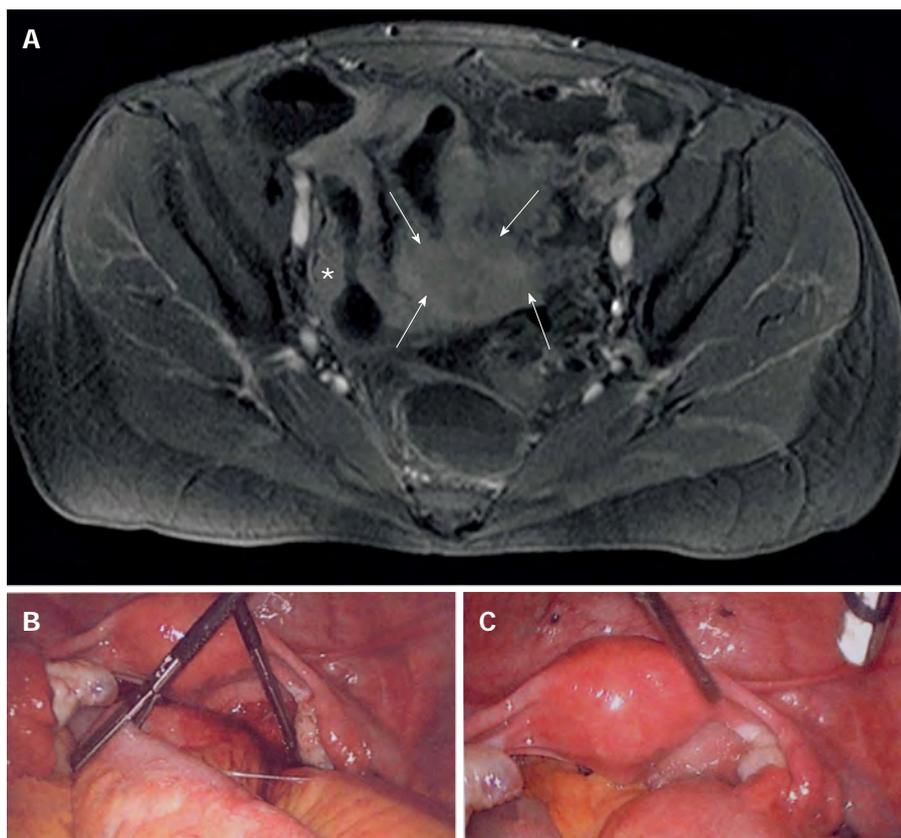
Radiological and surgical aspects of florid intestinal endometriosis and Crohn's disease coincidence. A: Magnetic resonance imaging-Sellink of the lower pelvis (axial T1 FS plus contrast agent). Bauhin's valve and coecum are marked with an asterisk. The arrows highlight an uncharacteristic tissue mass involving the bowel; B: Laparoscopically, adhesion of the distal small bowel to the pelvis wall; C: Brownish spots on the pelvis and bladder peritoneum are indicating for endometriosis.
